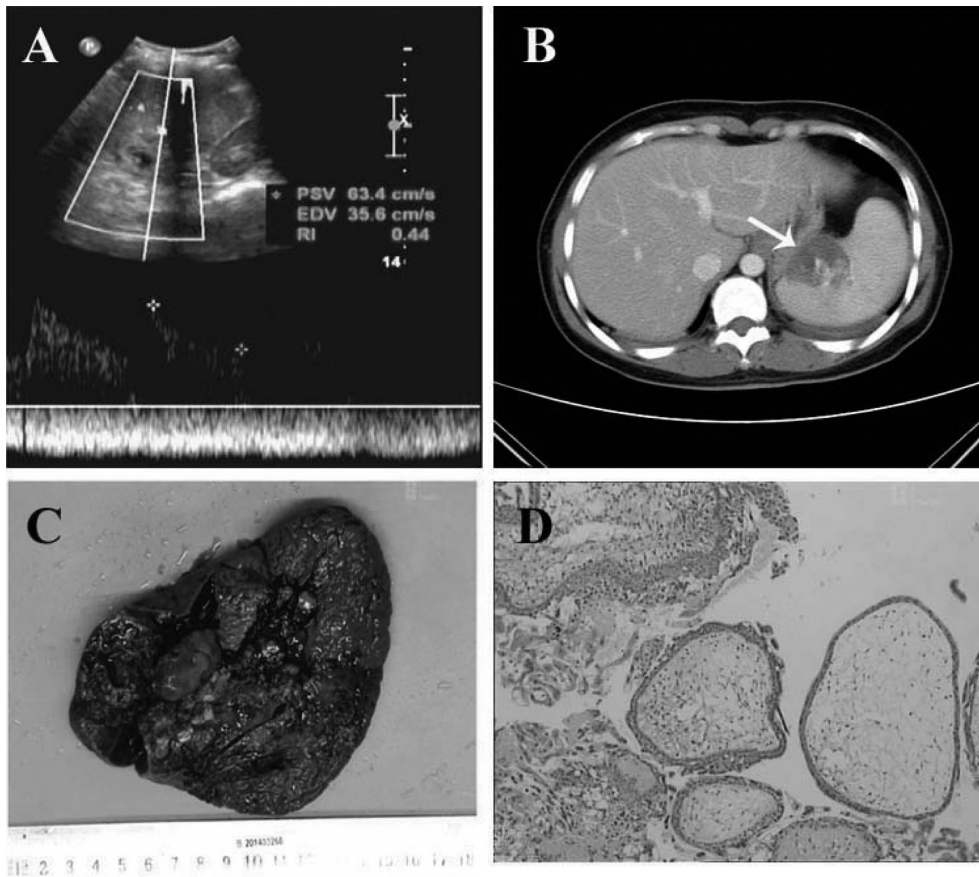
Successful management of primary splenic pregnancy. (A) Ultrasonography reveals middle-upper inside part of spleen exhibiting a mixed anechoic area. (B) CT scan reveals occupation in the inner part of hilus lienis (white arrow). (C) Mass is deep in splenic parenchyma with visible villosity inside. (D) Pathological examination reveals chorionic villi in the splenic foci.
